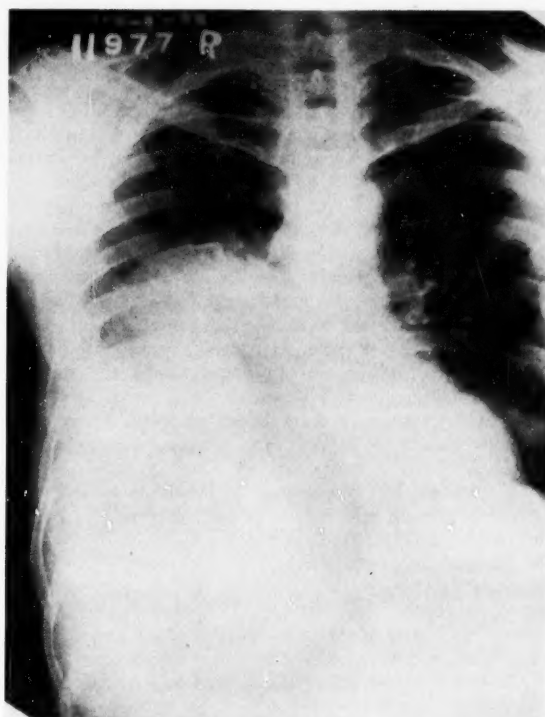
Chest x-ray of same patient (H. D.) on the 9th hospital day showing right pulmonary involvement.
